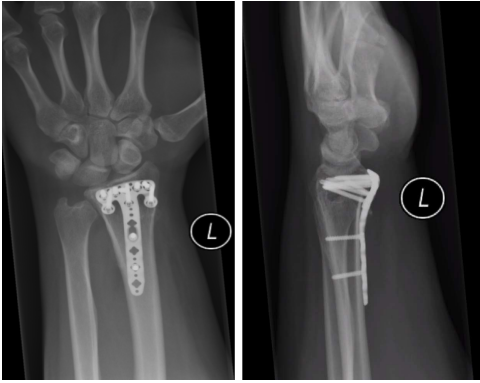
Posteroanterior and lateral radiographs of fracture fixation using a Synthes variable angle 2.4 distal radius rim plate to highlight the distal placement of the implant.
